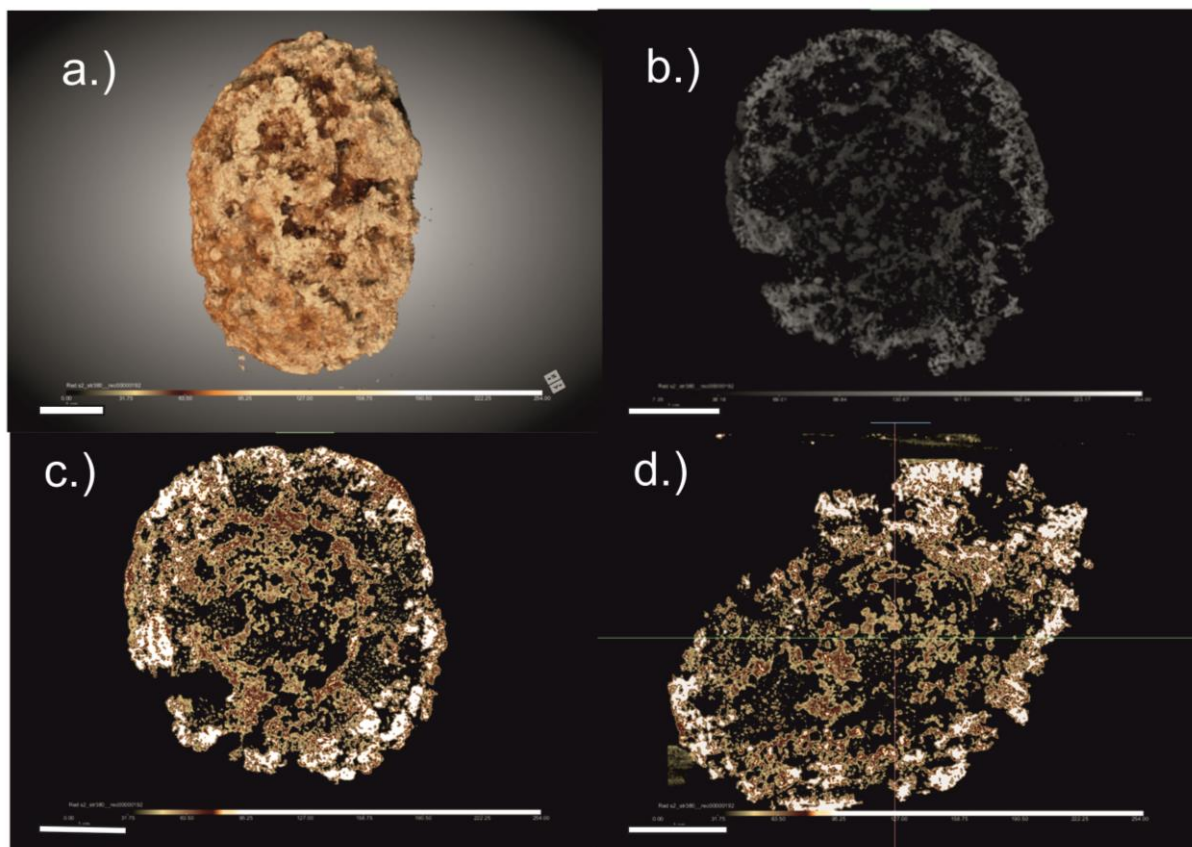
3D reconstruction (a) and 2D CT cross-sectional (b, c) and longitudinal (d) slices of the bladder stone (note coloring, resembles closely the original, multiple composition of different relative densities and radial structural organization of the calculus under study is also visible)
